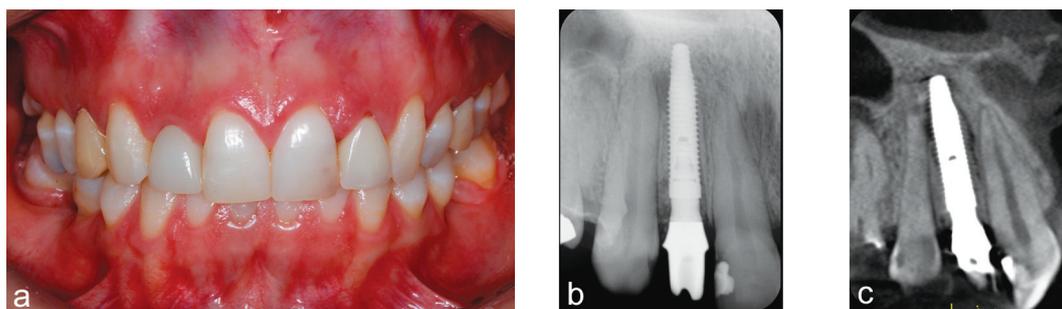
The 12-month follow up: intraoral clinical view (a); periapical radiograph (b); CBCT (c).
